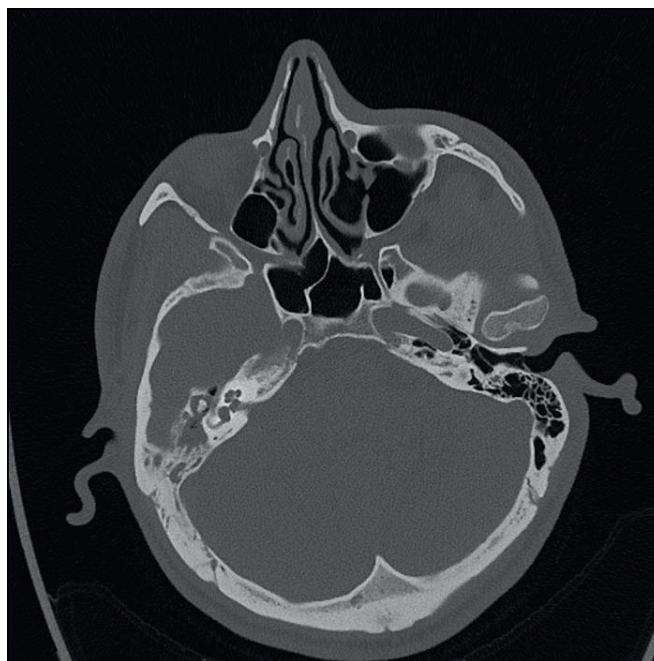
Axial temporal CT, unilateral COM (right).
